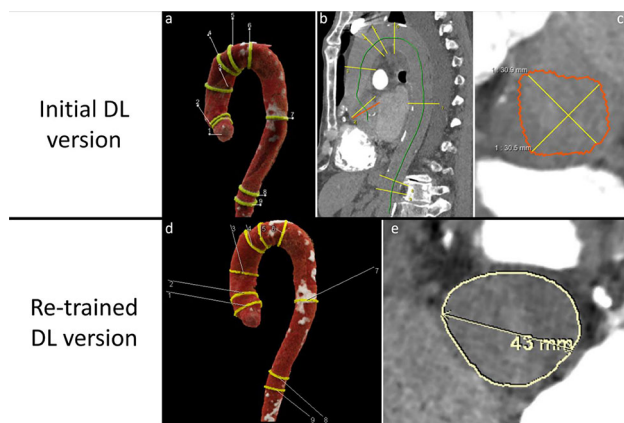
Initial (a-c) and re-trained DL (d,e) assessments in one non-CE chest CT case. Top row shows VRT (a), MPR (b) and axial through-plane at AS (c) using the initial DL version. The plane was tilted, leading to a false measurement. Bottom row (re-trained DL) shows improved plane placement on VRT (d) and improved aortic segmentation at AS
